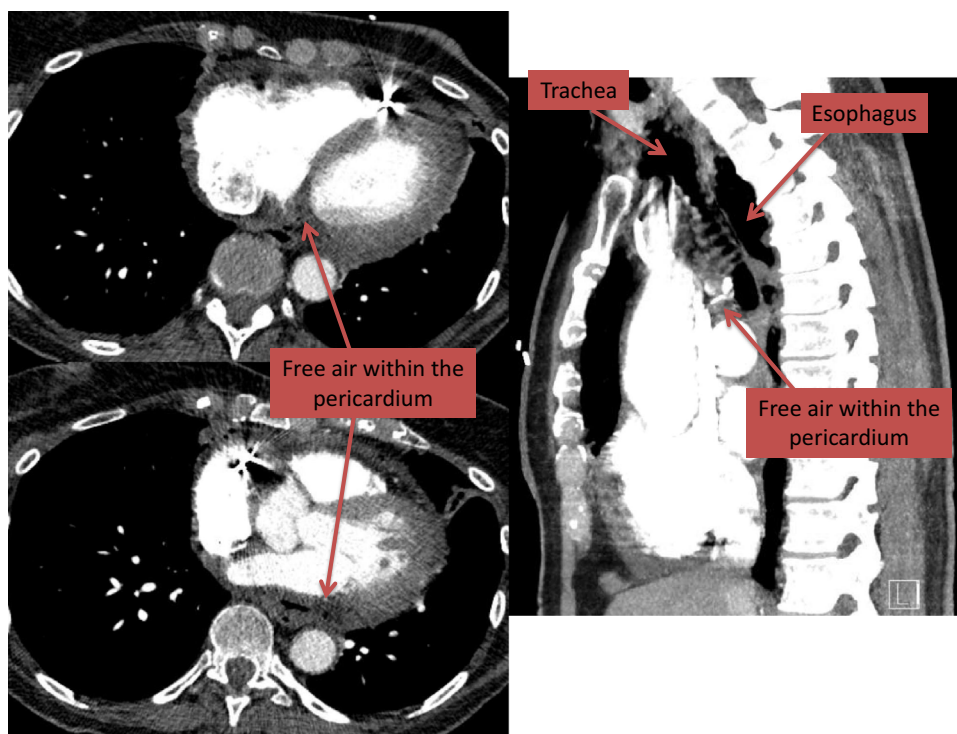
Chest computed tomography images showing free air within the posterior pericardium.
